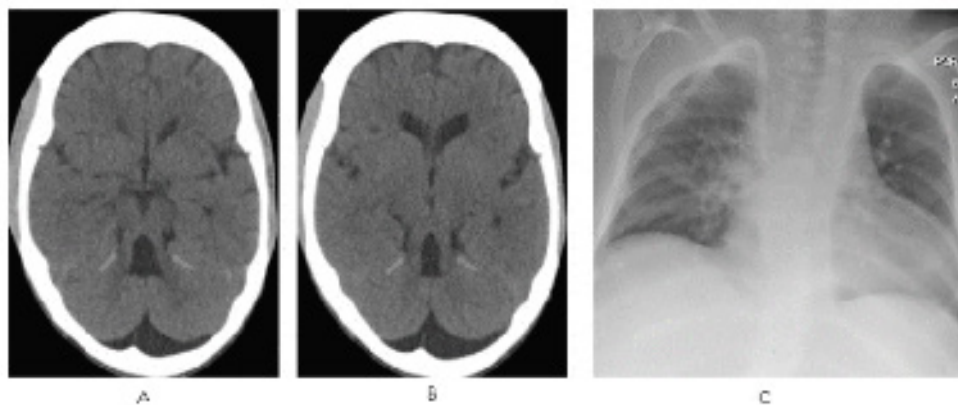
A, B, C: Axial CT non-contrast images (A, B) show hypoplastic vermis and elongated superior cerebellar peduncles (blue arrows) giving classical appearance of 'Molar Tooth sign'. Chest radiograph (C) shows diffuse cardiomegaly with bilateral perihilar vascular congestion with right central line.
